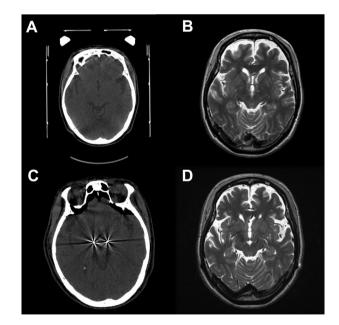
(A) Preoperative computed tomography and (B) magnetic resonance imaging were both performed for the stereotactic surgery and to localize the subthalamic nucleus. (C) Postoperative computed tomography and (D) magnetic resonance imaging were conducted to verify the electrode coordinates and to evaluate any neurological lesions, such as intracerebral hemorrhage.
